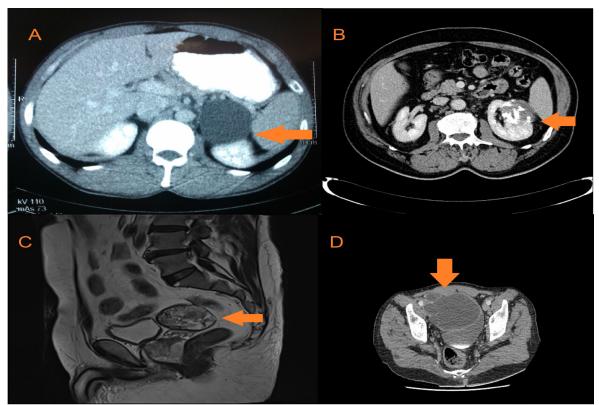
Retroperitoneal organs hydatid cyst (CH). A: Adrenal hydatid cyst; B: Renal hydatid cyst; C: Retrovesical hydatid cyst (MRI image of the cyst from the back wall of the bladder and seminal vesicles); D: Retrovesical hydatid cyst (CT image of the cyst from compressing bladder anterior wall and the patient had hydraturia)
